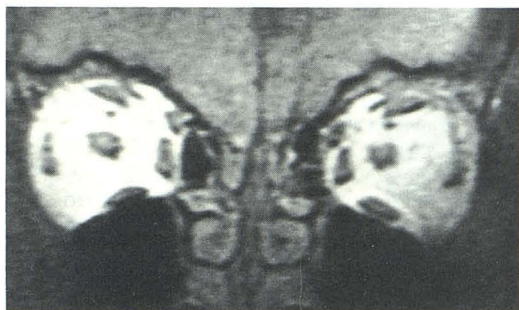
Orbital pseudotumor with hypointense orbital fat. Coronal surface-coil MR, T1-weighted image (TR = 600 msec, TE = 20 msec). Note diffusely decreased signal intensity of orbital fat on affected left side as compared with normal fat in contralateral orbit.
